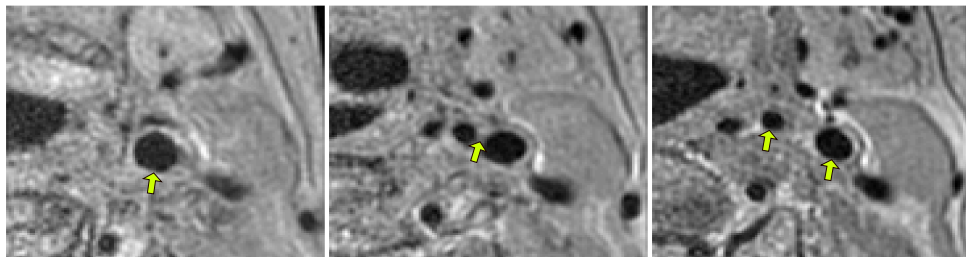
Cropped slices 10, 20, and 30 (left to right) of the left carotid of subject 1 in the carotid MRI data-set. The arrows point to the common carotid artery (left image), the carotid bifurcation point (center image), and the internal and external parts of the carotid after the bifurcation (right image).*
